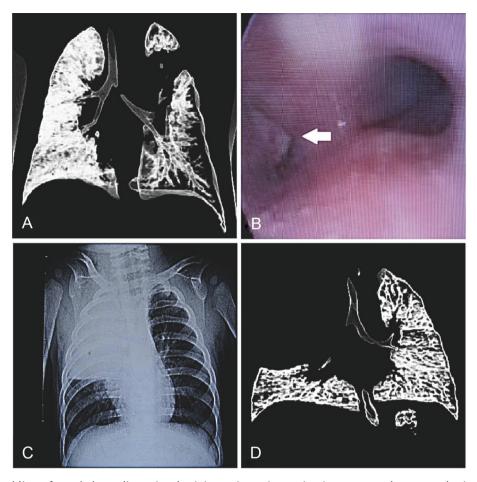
(A) An oblique frontal three-dimensional minimum intensity projection computed tomography image of the central airways and lungs shows a severe narrowing of the left main bronchus at the proximal portion. Note the left upper lobe atelectasis. (B) Bronchoscopy shows severely narrowed lumen of the left main bronchus at the level of carina. (C) Chest radiograph of the second patient shows the total opacification of the right upper lobe compatible with collapse. (D) Frontal three-dimensional minimum intensity projection computed tomography image of the central airways and lungs shows a severe narrowing of the right main bronchus, as well as right upper and lower lobe bronchus due to a vegetative mass. Note the right lobe atelectasis.
